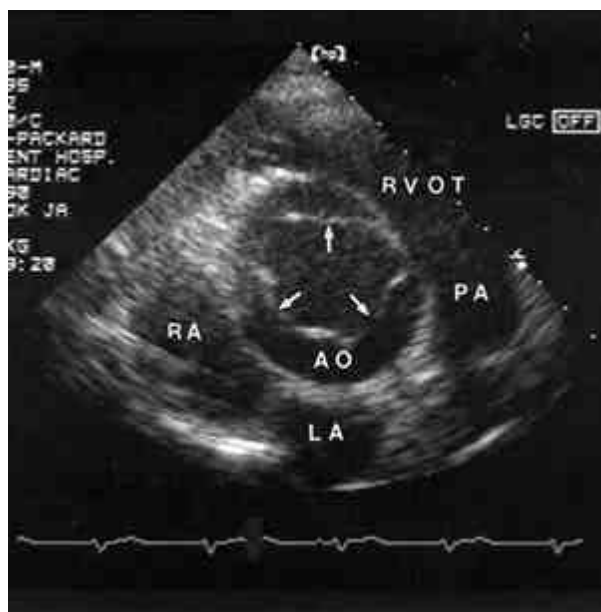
Transthoracic echocardiography revealing aneurysmal dilatation with a circular shaped intimal flap (arrows) at the aortic root (AO) level in the parasternal short axis view. LA=left atrium; PA=pulmonary artery; RA=right atrium; RVOT=right ventricular outflow tract
